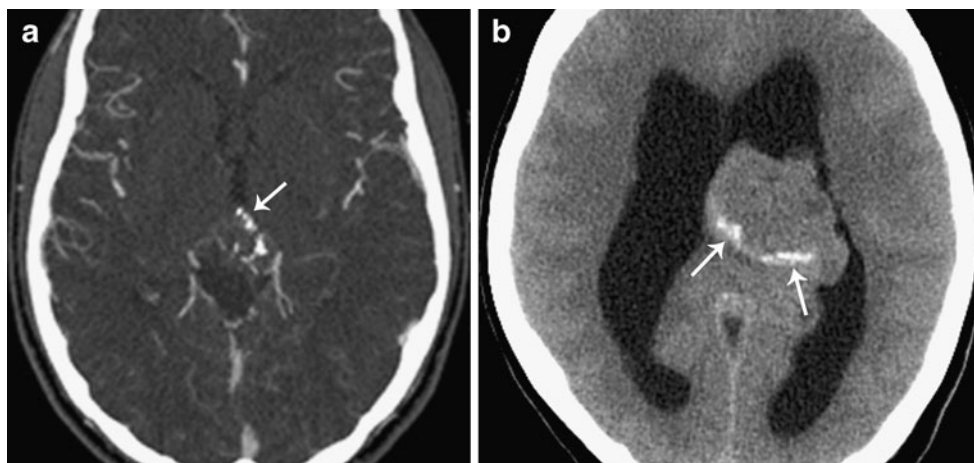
a Axial CTA image in an 18-year-old male presenting with HA (case 10) shows a pineal mass with peripheral “exploded” calcifications (*arrow*). b Axial non-contrast CT image of a 50-year-old female patient presenting with HA and incontinence (case 7) shows a
